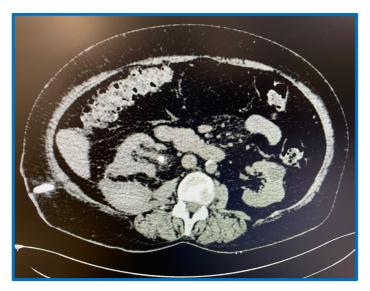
Figure 2. CT: Stone size has decreased by more than two-thirds. Approx. 500 HU. Laminar perirenal hematoma.
